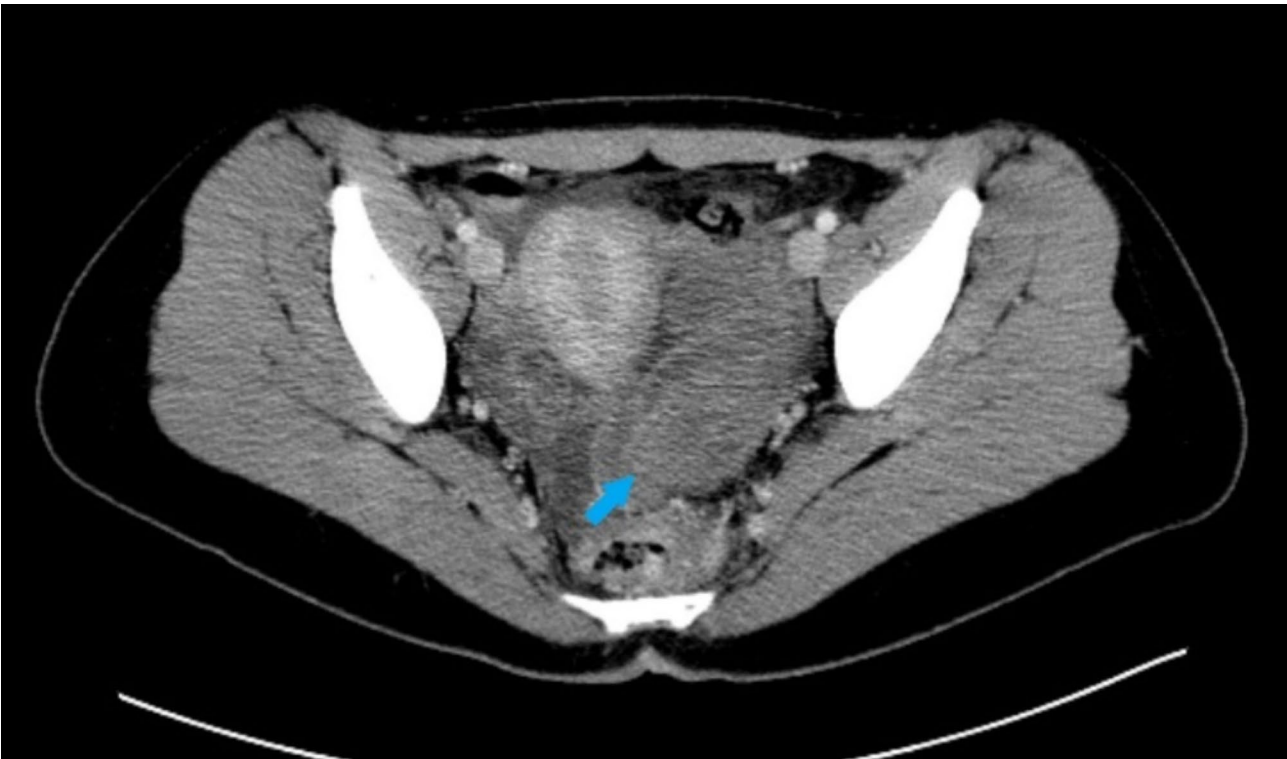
Abdominopelvic computed tomography scan suggesting a left tubo-ovarian abscess. Axial view abdominopelvic computed tomography scan displaying a complex tubular multilocular enhancing structure in the left adnexa associated with regional fat stranding within the pelvis as well as a small volume of pelvic free fluid (blue arrow). These findings are suggestive of a left tubo-ovarian abscess
